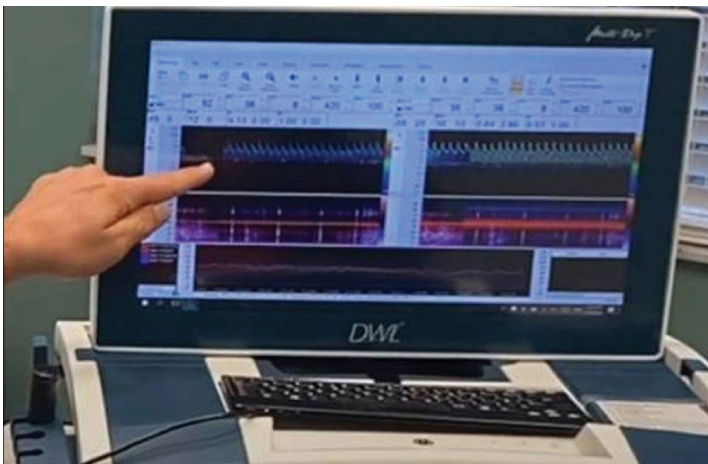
Middle cerebral artery ischemia observed during motion transcranial doppler examination. Cessation of the middle cerebral artery wave from (finger point) when patient held a certain neck position. Middle cerebral artery circulation was restored when she put her neck back in the neutral position.
